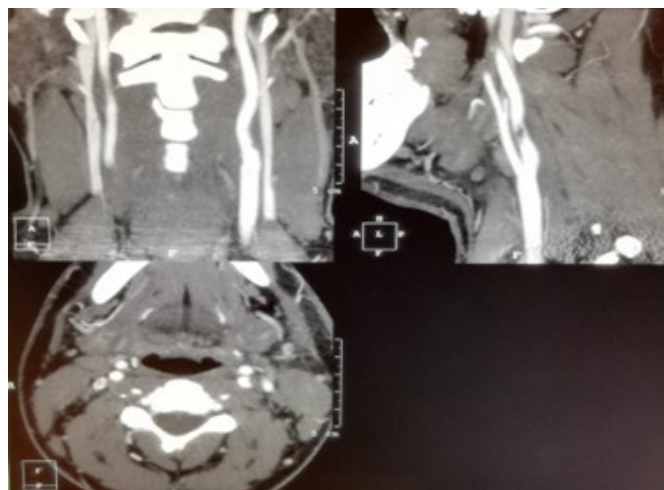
CT angiogram of the neck one week after the initial presentation in coronal, sagittal, and axial views showed regression in the previously noted thrombosis involving the left internal carotid artery at the level of C3-C4, with regaining of luminal patency (currently 33%); near-total vanishing of the intimal flap at the left common carotid artery; no evidence of extravasation; and resolution of the previously noted hematoma and surgical emphysema.
